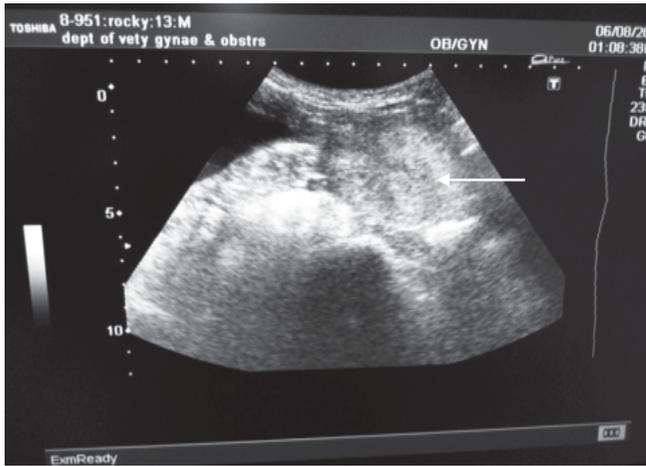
2D ultrasonogram showing symmetrical enlarged lobes (arrow) of the prostate gland.
